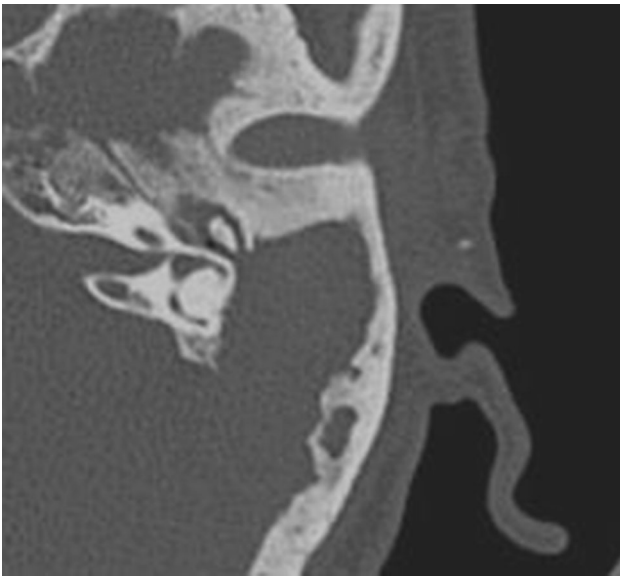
HRCT showing cholesteatoma eroding the posterior boundary of the mastoid cavity (subject 3)
